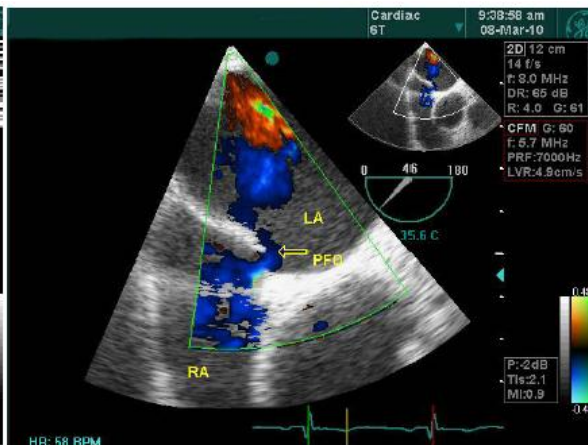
Color Doppler imaging revealed an interatrial left to right shunt across a patent foramen ovale (PFO). LA, left atrium; RA, right atrium
